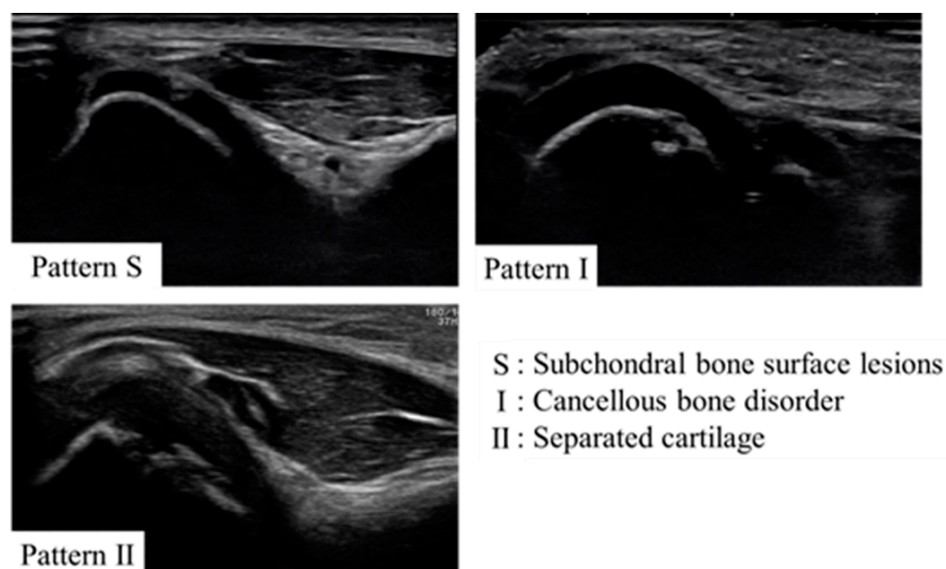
Characteristic ultrasound images of OCD extracted during the current screening are shown. This study followed Okada's pattern classification.
